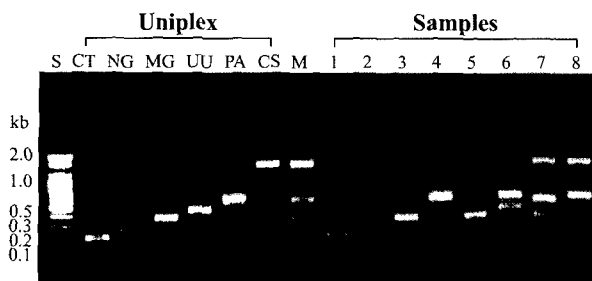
The capacity of mPCR to co-amplify six selected bacterial species. Lanes; S, standard marker; M, mPCR; CT, *C. trachomatis*; NG, *N. gonorrhoeae*; MG, *M. genitalium*; UU, *U. urealyticum*; PA, *P. aeruginosa*; CS, *Corynebacterium* spp.; M, mPCR. In the FVU, samples, (numbers 1 and 3-6 are from male STD patients, while 7 and 8 are from men with prostatitis syndrome. Number 2 is FVU from a healthy male).
